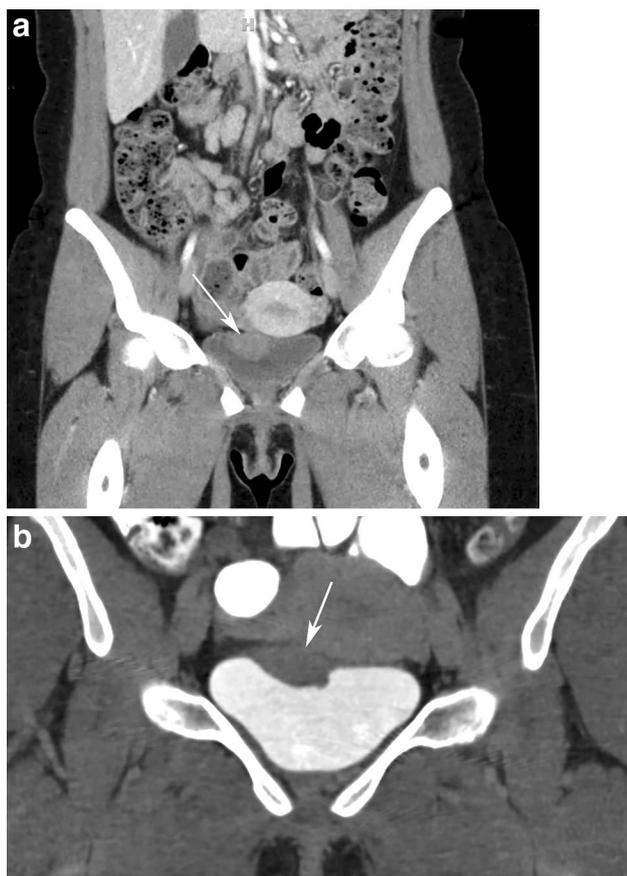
Bladder endometrioma. a A coronal reformatted portal venous phase contrast-enhanced CT image shows a large lobulated mass projecting into the bladder lumen, characteristically located at the bladder dome (arrow). b This lesion is also well seen on a coronal reformatted excretory phase image (arrow) (Images courtesy of Cary Siegel, Mallinckrodt Institute of Radiology, St. Louis, MO)
